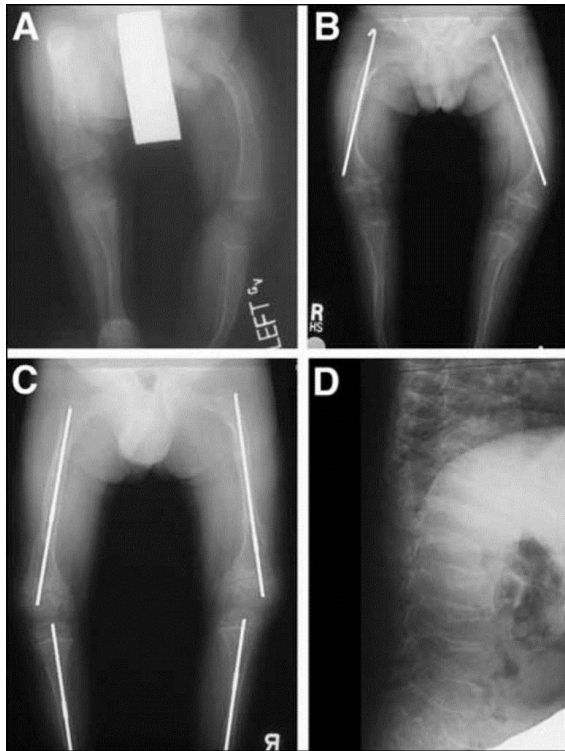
A, B: Radiographs of lower extremities of type III OI child. Shows osteoporosis, flared metaphyses, and placement of intramedullary Rush rod. C, D: Radiographs of child with type III OI. Shows lower long bones osteoporotic with cystic formation and “popcorn” metaphyses, and placement of telescoping intramedullary rods. Lateral view of spine shows anterior and central compression of multiple vertebrae.
